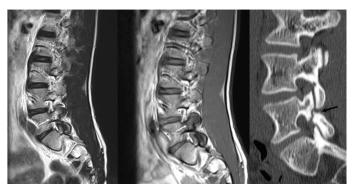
Seventeen-year-old man with spondylolysis and type 1 reactive marrow change at L5 level (arrows, A and B). It is characterized by increased signal intensity on T2-weighted images and decreased signal intensity on T1-weighted images. The sagittal reformatted CT scan confirms presence of defect in pars interarticularis at L5
